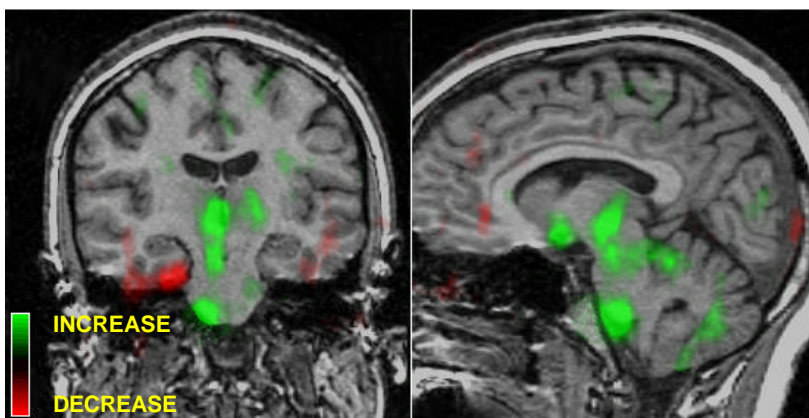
Example of a SPECT difference image super-imposed on an MRI. This patient had left temporal lobe seizures with marked hyperperfusion in the right medial thalamus, as seen in the coronal section above. These images were taken from patient 5 in Table 1. Note that the late SPECT injection (45 seconds post-ictal) is associated with activation of the contralateral medial thalamus.
